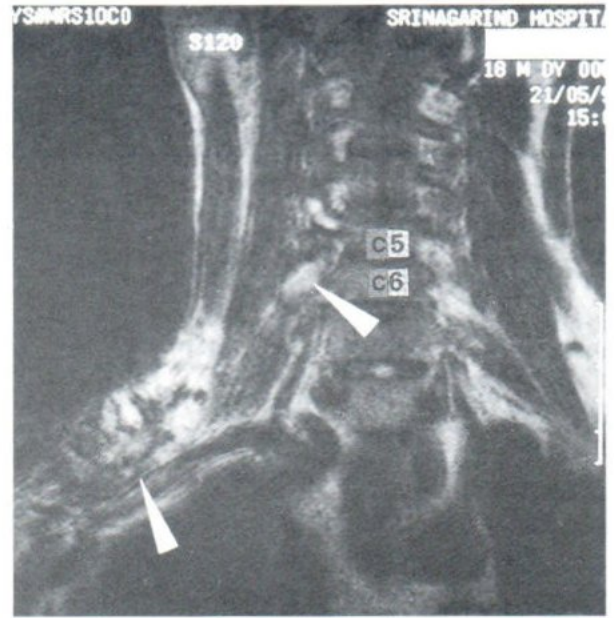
Oedema of Rt C6 root(upper arrowhead) and entrapment of upper and middle trunks by callus(lower arrowhead). MRI of the same patient as Fig.1.1
